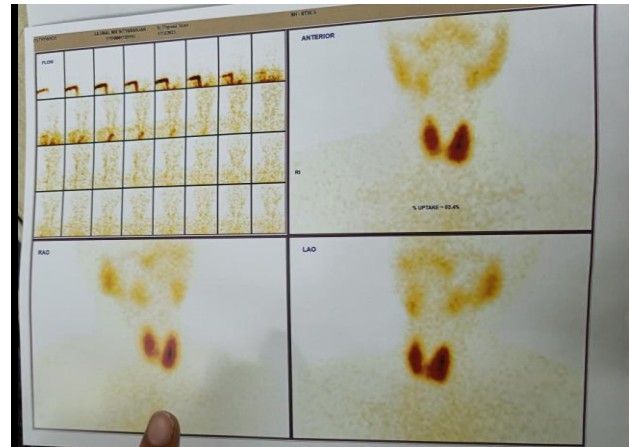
Thyroid scintigraphy showing avid trapping function possibility of subclinical graves.
